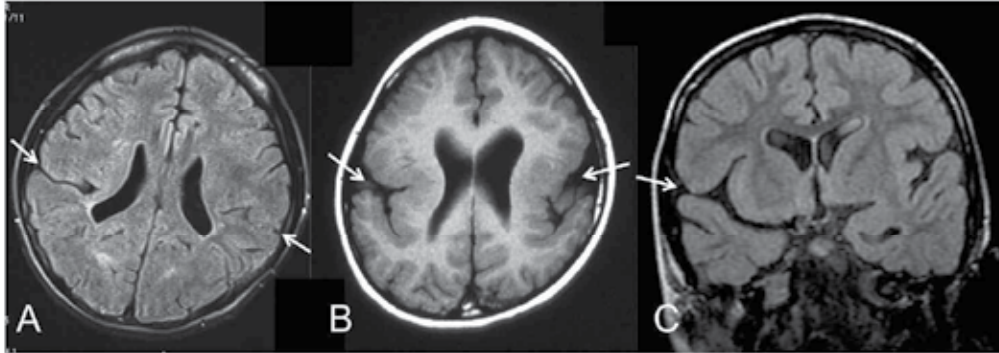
Brain magnetic resonance imaging (MRI) findings of three patients with perisylvian polymicrogyria. Fluid-attenuated inversion-recovery (TR/TE/ TI = 8002/133/2000 ms) (A, C), and T1-weighted MRI (TR/TE = 500/9 ms) (B). A: Case 1. Narrow and deep sylvian fissures (arrows) and their surrounding pachygyric cortex were found. B: Case 2. The bilateral perisylvian cortical dysplasia are accompanied with bilateral dysplastic insula (arrows). C: Case 3. Note the dysplastic right perisylvian cortex with broad and thickened gyri (arrow).
